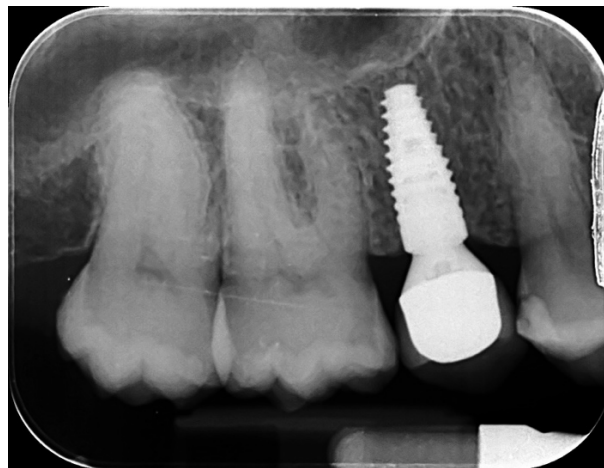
Periapical x-ray of a healthy implant
